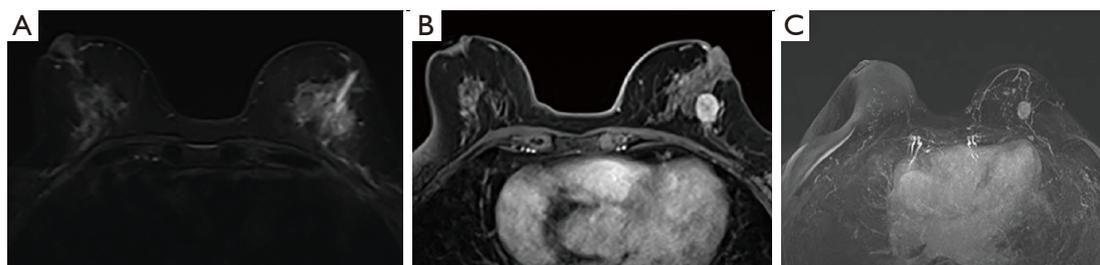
Female, 71 years old, 6 years after the operation for right intraductal papilloma, found left lacteal discharge for one month. T2WI of MRI (A) showed a slightly hyperintense lesion in the lateral posterior region of the left breast with an anterior dilated catheter. The MRI obtained in the post-contrast phase (B) showed annular enhancement of the left lateral breast mass, BI-RADS 4B. The MIP of the MRI (C) showed mild BPE in the left breast. The pathology of the core needle biopsy showed an intraductal papillary tumor with atypical ductal hyperplasia; the pathology was not upgraded after surgery. T2WI, T2-weighted image; MRI, magnetic resonance imaging; BI-RADS, Breast Imaging Reporting and Data System; MIP, maximal intensity projection; BPE, background parenchymal enhancement.
